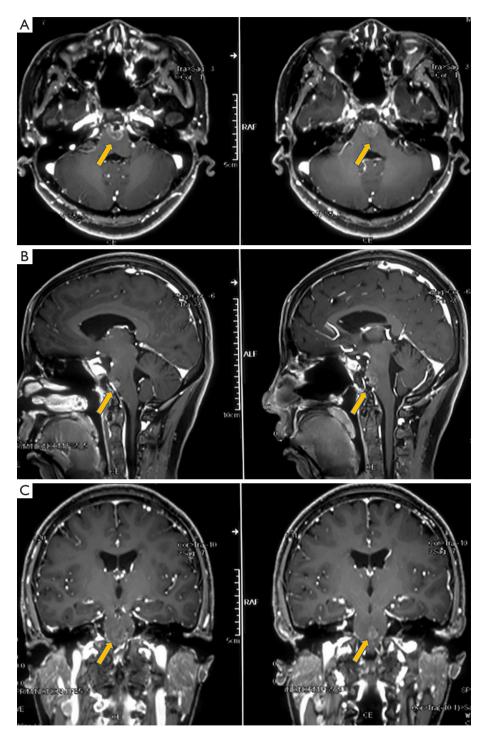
Follow-up MRI of the clival chordoma recurrence *in situ* 10 months after endoscopic surgery. MRI showed a recurrent lesion of approximately 6 mm × 7 mm × 8 mm located *in situ* (arrows) and no lesion was seen in the spinal canal at C1 to C2 level (A, axial plane; B, sagittal plane; C, coronal plane). MRI, magnetic resonance imaging.
